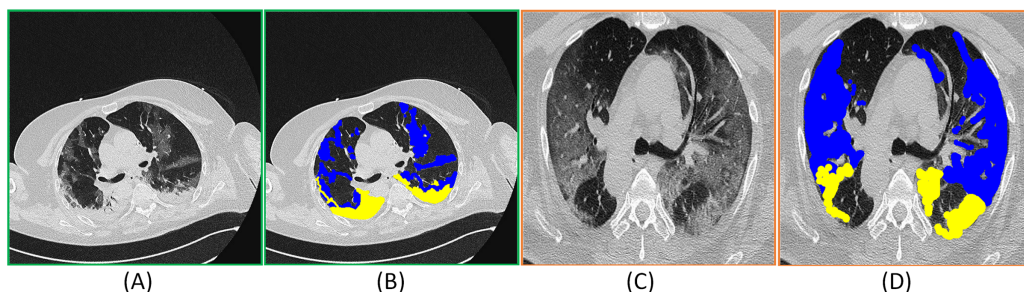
(A) and (C) represent the CT images and (B) and (D) correspond to the COVID-19 infected areas in CT axial section. Here the blue and yellow masks represent the Ground Glass Opacity(GGO) and the late lung consolidation segments respectively. The images were obtained from (MedSeg, 2020). Full-size  DOI: 10.7717/peerj-cs.349/fig-1
